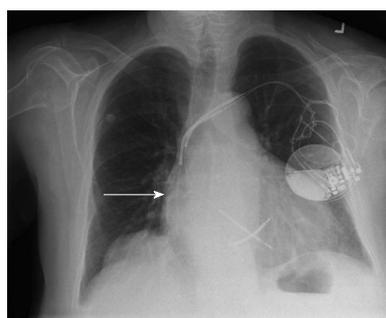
Chest X-ray. A: Normal appearing lead without any twirling; B: A visible twirling is seen at right atrio-ventricular junction (arrow).
